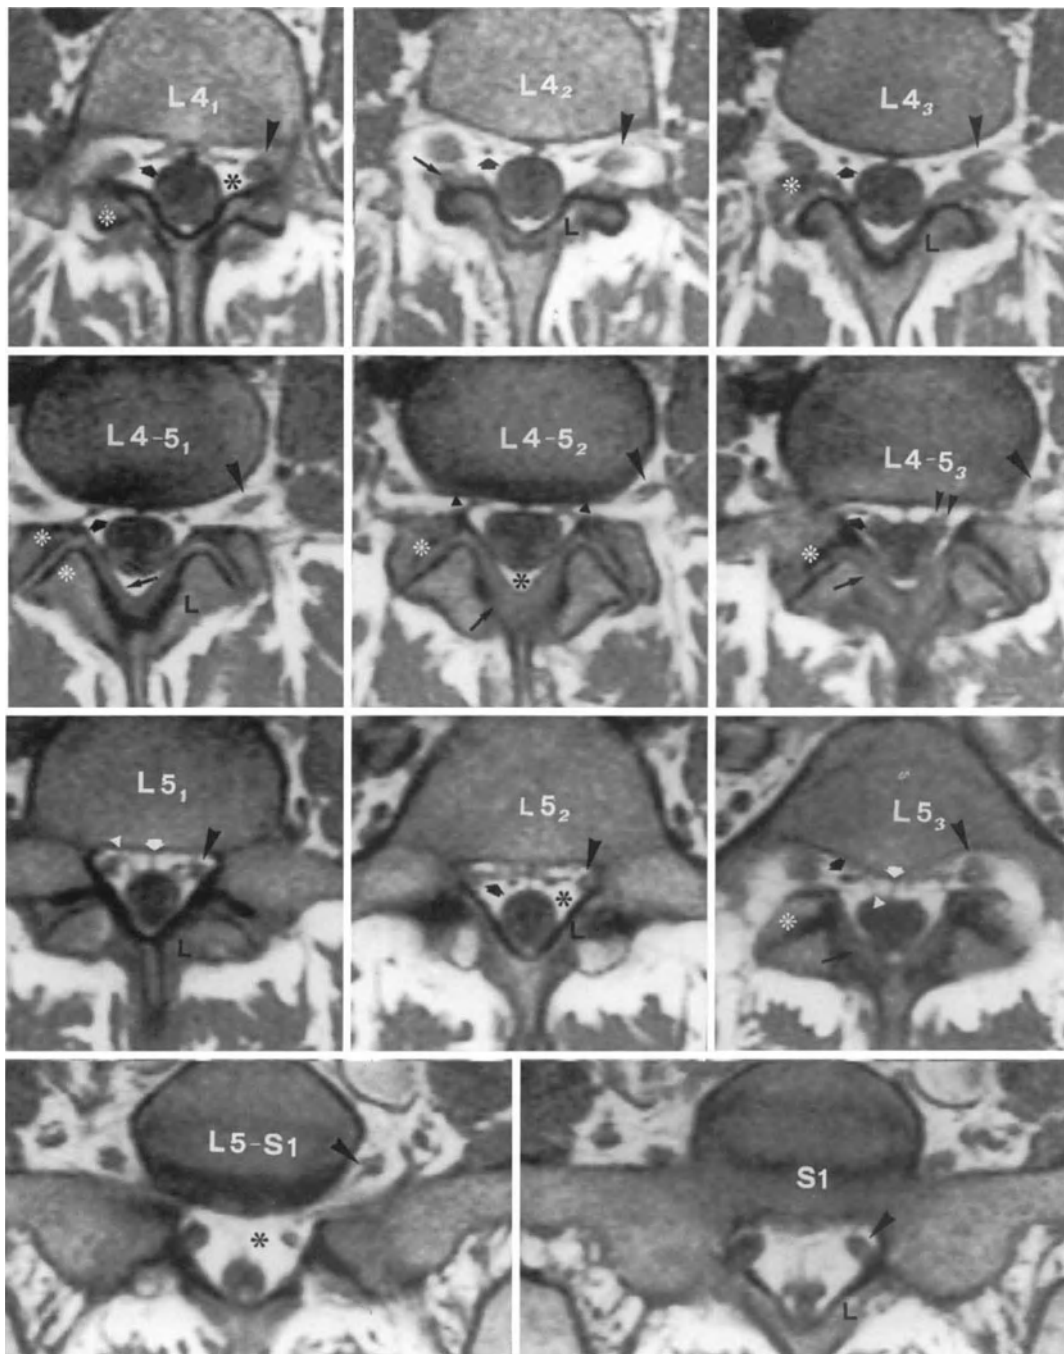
Spin-echo T1-weighted axial MR images. The images are sequential from the caudal half of the L4 vertebra to the S1 vertebral end-plate. The arrowheads indicate the L4 nerve root in the L4 radicular canal (L4₁) and the L4-L5 intervertebral foramen (from L4₂ to L4-5₃), the L5 root in the L5 radicular canal (L5₁, L5₂) and the L5-S1 intervertebral foramen (L5₃, L5-S1), and the S1 root in its radicular canal (S1). The double arrowheads indicate the L5 root emerging from the thecal sac (L4-5₃); the nerve roots are visible, in the sac, as roundish structures displaying a similar signal intensity to the CSF. The short arrows point to the anterolateral venous plexuses of the spinal canal. The black asterisks indicate the considerably hyperintense epidural fat. The white asterisks are placed on the superior articular processes of L5 (from L4₃ to L4-5₃) and S1 (L5₃). At L4-5₁ level, an asterisk is placed between which there is a hypointense zone corresponding to the articular cartilage. The white arrow indicates the median meningovertebral ligament and the triangle indicates the lateral meningovertebral ligament (L5₁, L5₃). The long arrows indicate the ligamenta flava. The black triangles at L4-5₂ level indicate linear structures, probably represented by the ligaments in the intervertebral foramen. L indicates the laminae of L4 (from L4₂ to L4-5₁), L5 (L5₁, L5₂) and S1 (S1). Note the signal hypointensity of the disc compared with that of the vertebral body; the areas showing lower signal intensity at L5-S1 and S1 correspond to portions of the disc.
